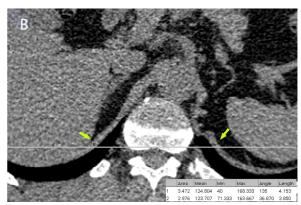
Measurement of DT on chest CT. (A) The CT cross-sectional images were evaluated in the mediastinal window at the level of the outlet of the celiac trunk, and the intersection between the horizontal tangent line of the anterior edge of the spinal canal and the lateral margins of the diaphragm was selected as the measuring point. (B) Image J software was used to measure DT based on CT imaging. The DT was measured vertically to the surface of the diaphragm.
